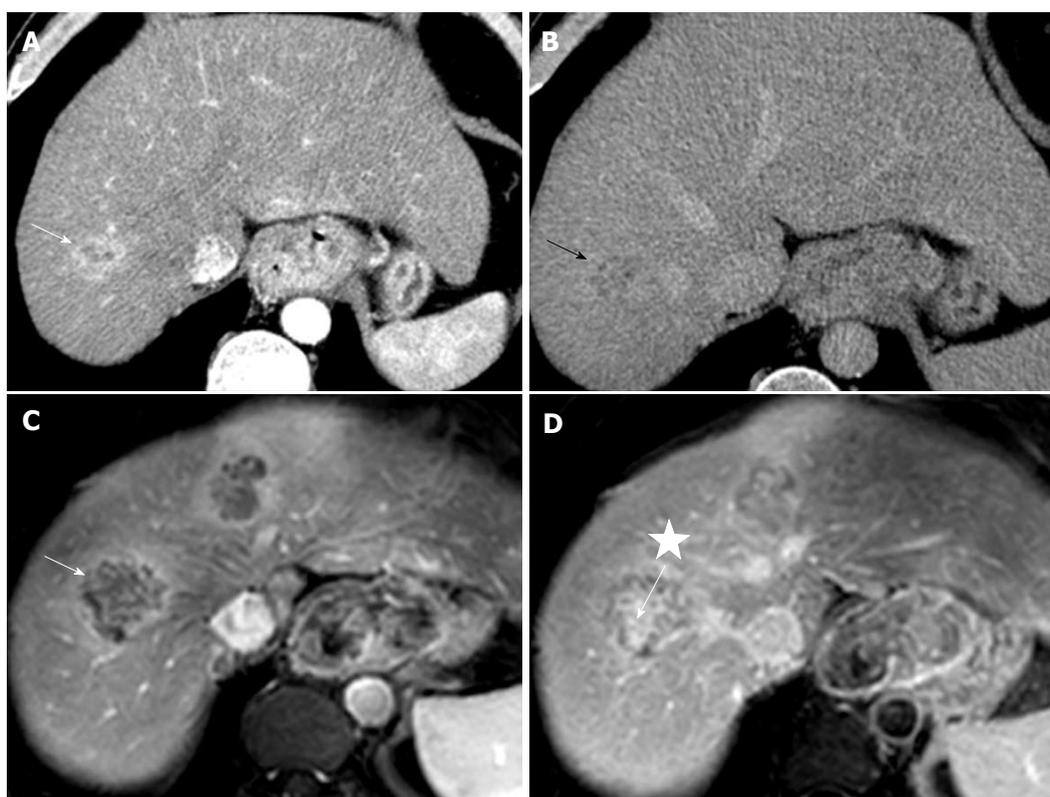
Computed tomography scan and magnetic resonance imaging scan imaging. Axial-enhanced computed tomography scans with arterial (A) and 5-min delayed times (B). Corresponding axial enhanced MRI in T1-weighted sequence with fat suppression (C and D). Tumor of the junction of the segments VIII-VII combined the double imaging features with peripheral arterial contrast enhancement (white arrow) and secondary wash out (black arrow) (HCC part) and a late fibrous contrast enhancement of the central part (white asterisk) (ICC part). MRI was performed at 2-mo intervals and demonstrated a second tumor with comparable behavior in segment IV. CT: Computed tomography; MRI: Magnetic resonance imaging.
